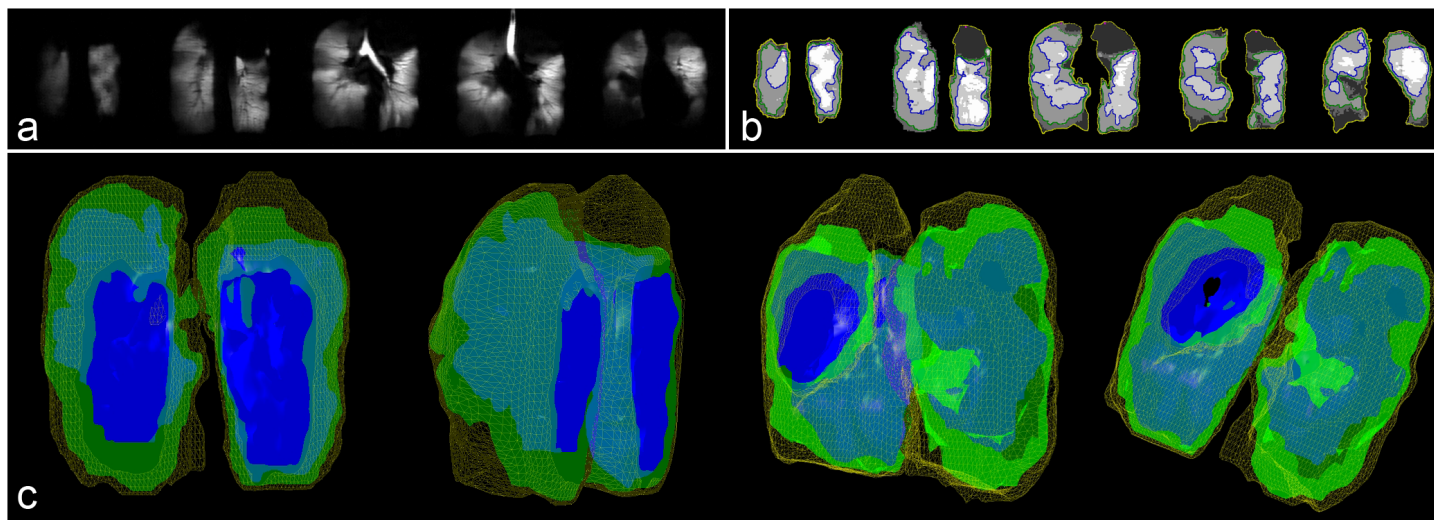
Fully rotational 3d surface of segmented regions of gas distribution in the helium lung. a) Hyperpolarized helium-3 MRI lung images. b) Contours of k-means clustering of helium-3 images. c) 3d surface rendering of contoured clusters. Blue contour and surface bounds the ventilated and hyper-ventilated regions, green bounds the hypo-ventilated regions and yellow bounds the ventilation defect regions.
